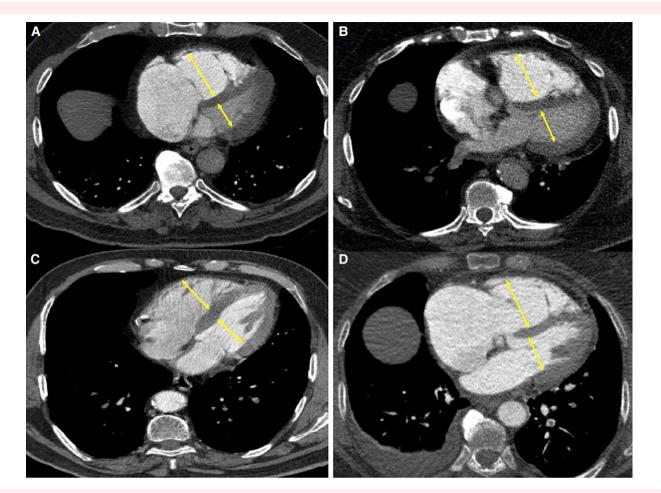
Computed tomography pulmonary angiography axial view shows right to left ventricular diameter ratio (RV/LV ratio): (A) Patient 1, RV/LV ratio = 1.6; (B) Patient 2, RV/LV ratio = 1.3; (C) Patient 3, RV/LV ratio = 1.1; (D) Patient 4, RV/LV ratio = 1.4.
